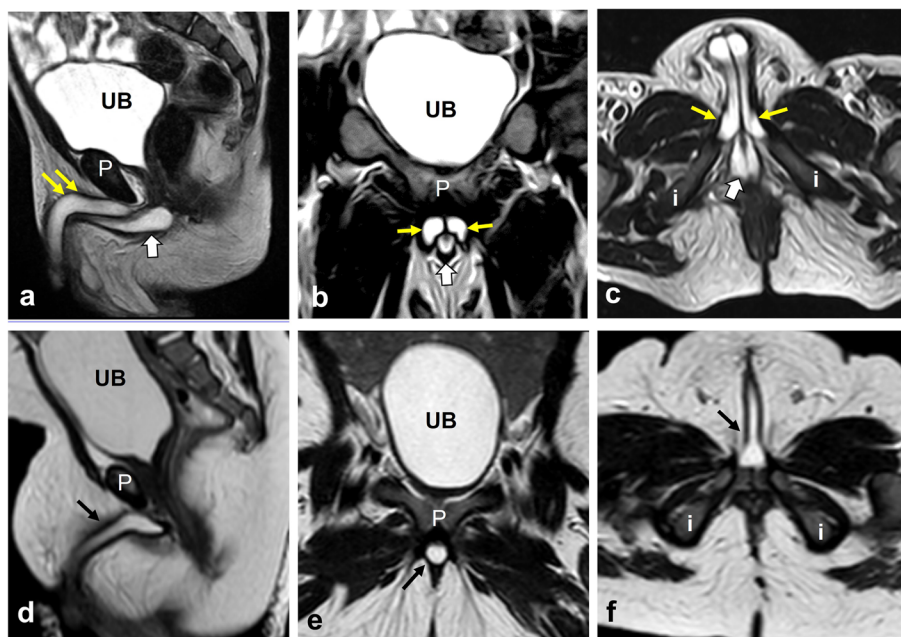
Penile corporeal dysgenesis in the so-called Y-type urethral duplication compared to normal control. Upper row (a, b, and c): Pelvic MRI (sagittal, coronal, and axial, respectively) of a 24-month-old boy (control) demonstrating normal anatomy: two dorsal corpora cavernosa (yellow arrows) and ventral corpus spongiosum (white arrow). Lower row (d, e, and f): Pelvic MRI (sagittal, coronal, and axial, respectively) of a 5-month-old boy with accessory urethro-anal tract. Note that the three corporeal bodies in the control (upper row) are replaced by a single corporeal body (single black arrow) in the case with accessory urethro-anal tract (lower row). UB, urinary bladder; P, pubic symphysis; i, ischial tuberosity
